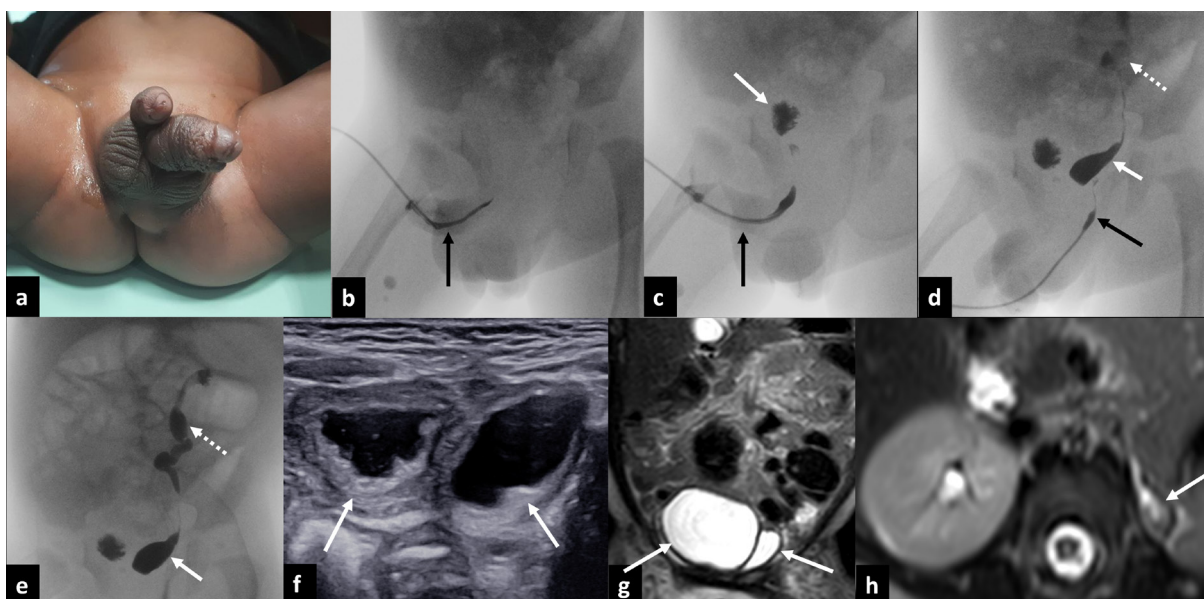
(a) Clinical photograph showing diphallia. (b-c) Retrograde urethrogram of the upper phallus reveals opacification of a distinct urethra (black arrows) and communication with one of the two separate urinary bladders (white arrow in c). (d-e) Retrograde urethrogram of the lower phallus shows opacification of the second distinct urethra (black arrow in d) and its communication with the second urinary bladder (white arrows in d and e). There is also contrast opacification of the dilated and tortuous left ureter and left pelvicalyceal system, indicative of vesicoureteral reflux (dotted arrows in d and e). (f) Gray-scale ultrasound showing duplicated urinary bladders (white arrows). (g-h) Magnetic resonance imaging confirming duplicated urinary bladders (white arrows in g) and a small left kidney (white arrow in h).
